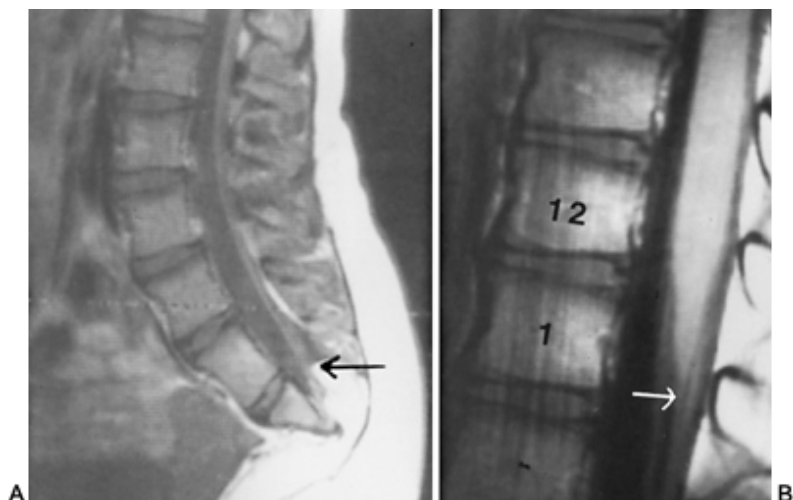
13. A: Magnetic resonance imaging (MRI) scan of normal lumbosacral spine. Conus (arrow) ends at L-1. B: MRI scan of patient with tethered cord and partial sacral agenesis. Conus (arrow) ends at L-5.
